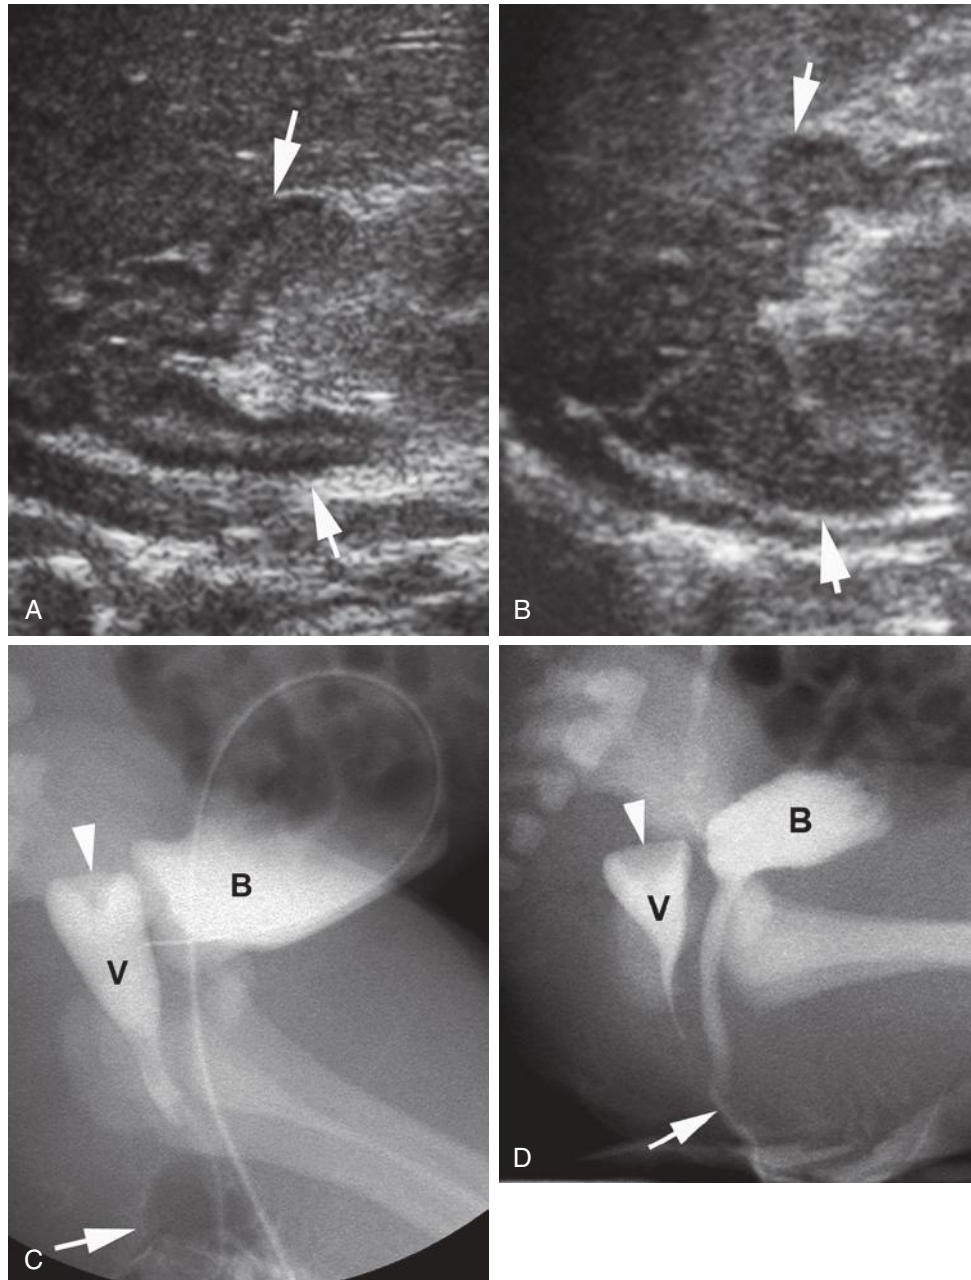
Congenital adrenal hyperplasia in a neonate with clitoromegaly. A and B, Sagittal ultrasound images reveal large, cerebriform right (A) and left (B) adrenal glands (*arrows*). The outer cortex is hypoechoic, whereas the central medulla is echogenic. C, Sagittal image from retrograde genitography shows a catheter placed through the common perineal channel and coiled within the bladder (B). A Foley catheter with air-inflated balloon (*arrow*) was also placed with its tip in the common perineal channel. Injected contrast material outlines the vagina (V) with a cervical impression (*arrowhead*) at its apex. D, The distal vagina unites with the urethra to form a common perineal channel (*arrow*). B, bladder; V, vagina; *arrowhead*, cervical impression.
